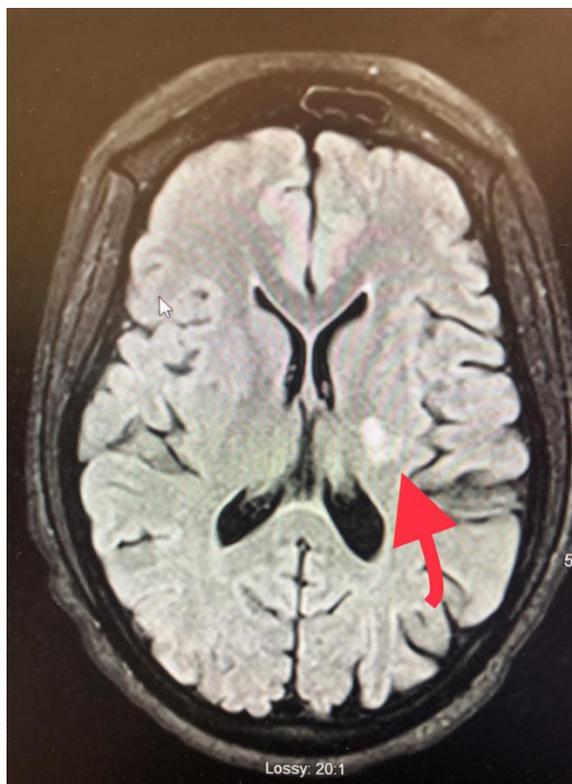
MRI brain showing small acute infarct in the posterior limb of the left internal capsule.
